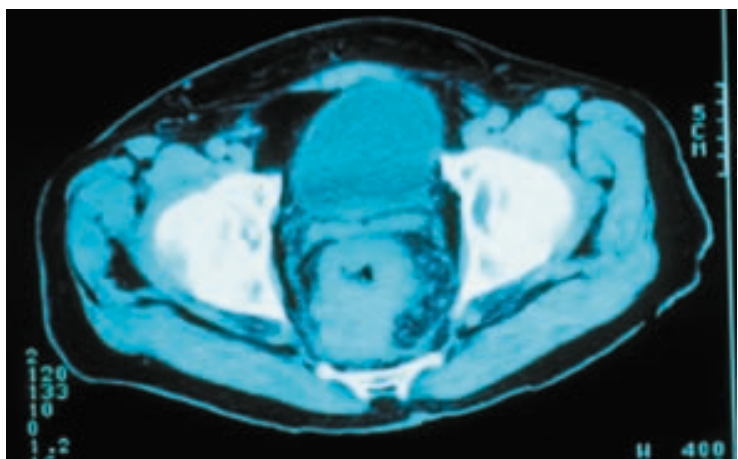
Computed tomography scan showing local recurrence of rectal tumour following surgery.
